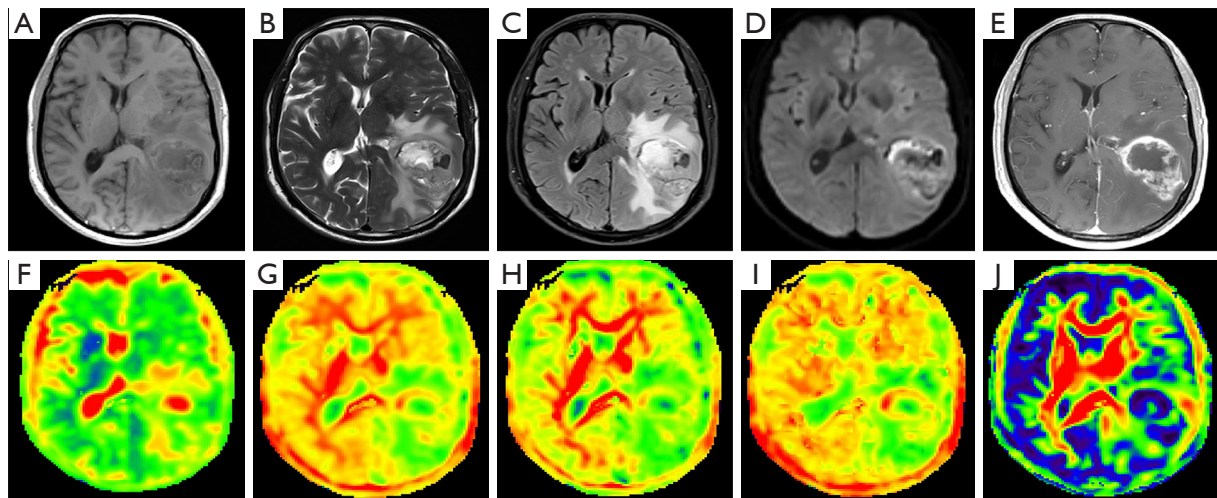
A 68-year-old male with HGG in the left temporal-parietal lobe (grade 4, Ki-67 = 80%). (A) The mass shows mixed signal intensities on T1WI, with a clear boundary. (B,C) The mass shows high intensity and nodular-like hypointense on T2WI and FLAIR, accompanied by peritumoral edema and cortical involvement. (D) The mass shows inhomogeneous hyperintensity on DKI ($b=1,000 \text{ s/mm}^2$). (E) Contrast-enhanced T1WI of the mass shows a marked enhancement rim, accompanied by SVI; (F) MD map; (G) MK map; (H) Kr map; (I) Ka map; (J) FA map. HGG, high-grade glioma; T1WI, T1-weighted imaging; T2WI, T2-weighted imaging; FLAIR, fluid-attenuated inversion recovery; DKI, diffusion kurtosis imaging; SVI, subventricular involvement; MD, mean diffusivity; MK, mean kurtosis; Kr, radial kurtosis; Ka, axial kurtosis; FA, fractional anisotropy.
